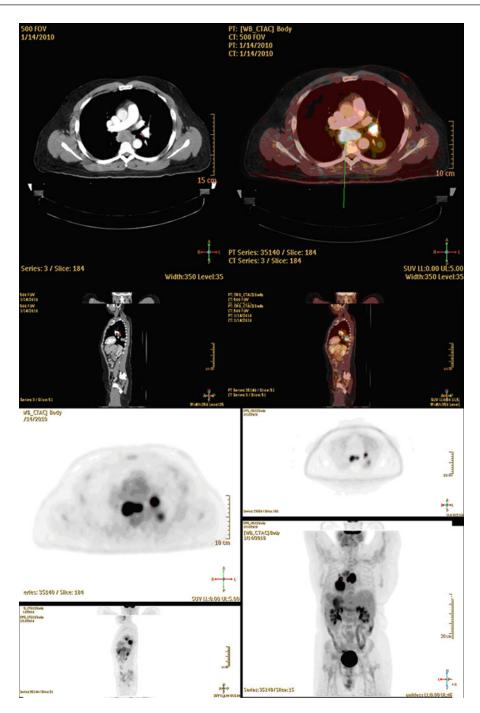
A PET-CT scan demonstrating the primary site of disease in the left lung and the mediastinum
